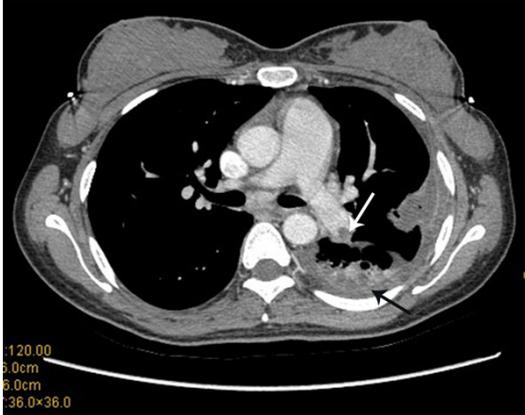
Preoperative enhanced chest CT showing thrombus in left distal pulmonary artery (thin arrow), and consolidation and atelectasis in left lower lung (thick arrow).
